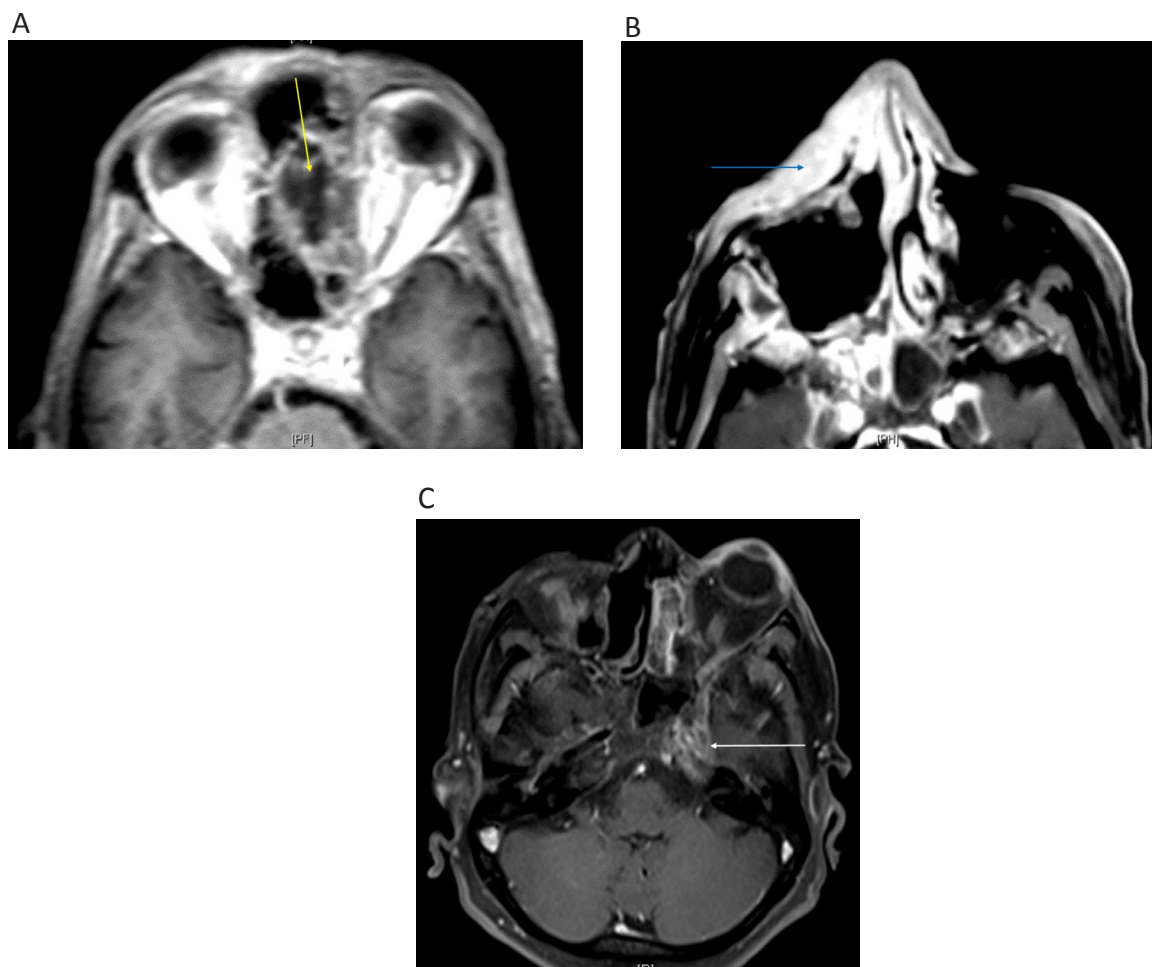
MRI post contrast enhancing patterns in mucormycosis. T1 post contrast MRI showing A. Hypointense pattern involving left ethmoid sinus (yellow arrow) B. Intense enhancement pattern in the left premaxillary region (blue arrow). C. Heterogeneous enhancement pattern in the left ethmoid and surrounding the left internal carotid artery (white arrow).
